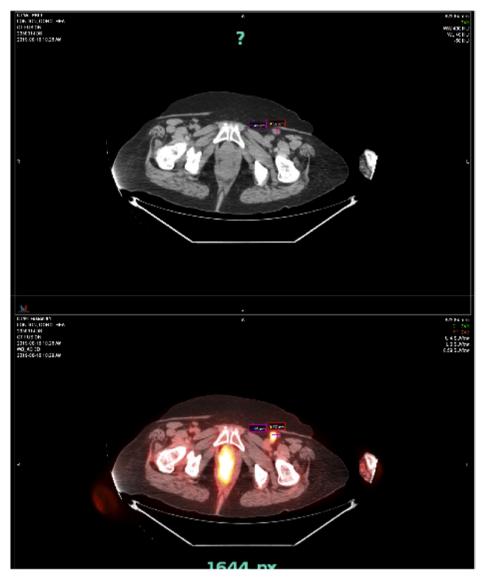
PET-CT images showing increased metabolic activity in the distal vagina and left groin that corresponds to a 1.5×1 cm left inguinal lymph node.
